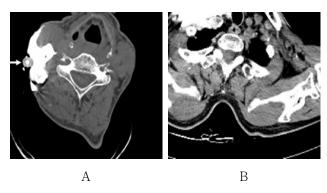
Transverse CT shows a large of contrast media of right neck and thorax. A, CT axial image of external jugular vein with resident IV Teflon catheter(arrow), demonstrating contrast media extravasation into the neck. B, Contrast media extravasated in the thorax area
